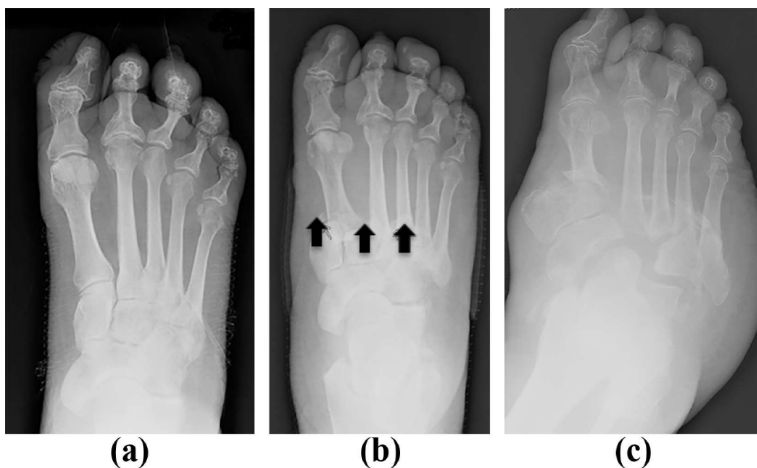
Progression of a foot Charcot neuroarthropathy on plain radiographs: (a) Initial anteroposterior view of an acute Charcot neuroarthropathy foot; (b) 6-month follow-up, which shows the persistent and progressive joint effusion, narrowing of the joint space, soft tissue calcification, minimal subluxation, osteopenia, and bone fragmentation; and (c) 2-year follow-up, which shows severe destruction of the foot without proper management.
